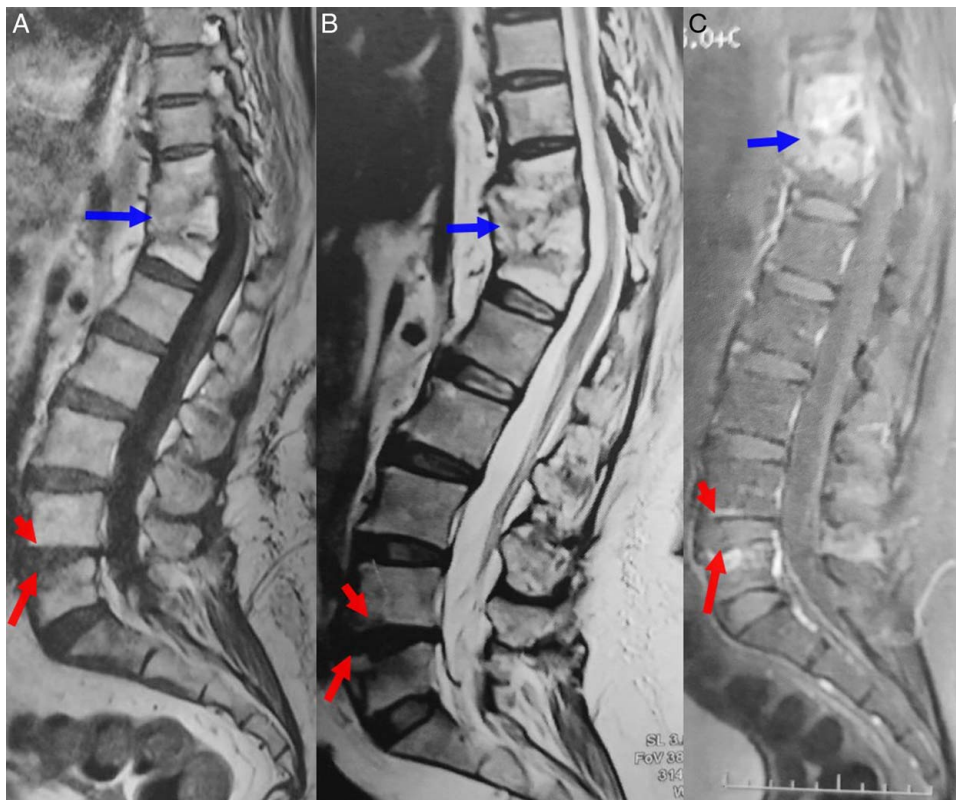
Spinal MRI in sagittal plane showing a destruction, angulation, and anterior compression of the vertebral bodies of D10, D11, and D12 having an isosignal on both T1 (A, blue arrow) and T2 sequences (B, blue arrow), with minimal heterogeneous enhancement after gadolinium injection (C, blue arrow) of the vertebral bodies and discs. At the lumbar level, there was an irregular appearance of L4-L5 endplates with hyposignal on T1-weighted-image (A, red arrow) and hypersignal on T2 sequence (B, red arrow), and heterogeneous enhancement after gadolinium injection (C, red arrow) of the vertebral bodies.
